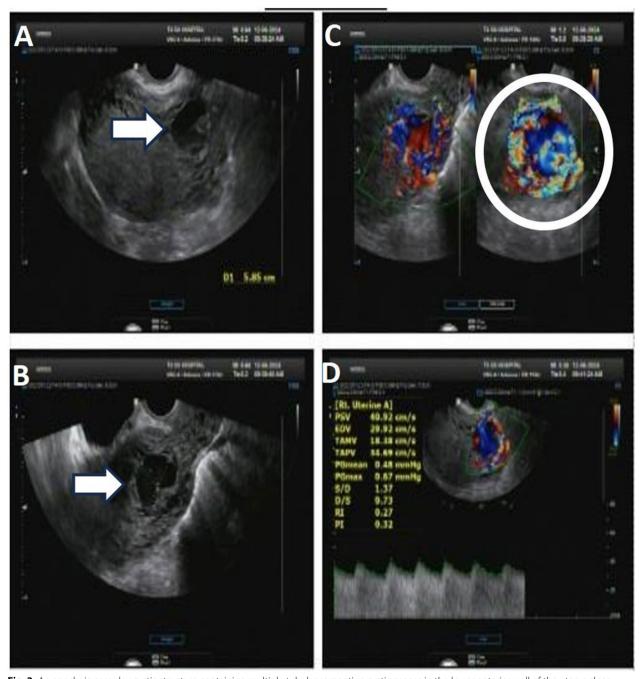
An anechoic complex cystic structure containing multiple tubular serpentine cystic spaces in the lower anterior wall of the uterus close to the site of the previous cesarean scar of the lower uterine segment (white arrow). Hypervascular mass located at the cesarean section site, presumably representative of cesarean scar pregnancy. The endometrial lining was thin with no signs of intrauterine or extrauterine gestation (A–C). Color Doppler ultrasound sagittal view of the uterus shows tortuous structure with mixed arteriovenous flow, color aliasing, and flow reversal as well as an increased peak systolic velocity of 40.92 cm/second, and a low resistive index of 0.27, indicating possible arteriovenous malformation (white circle) (D)
